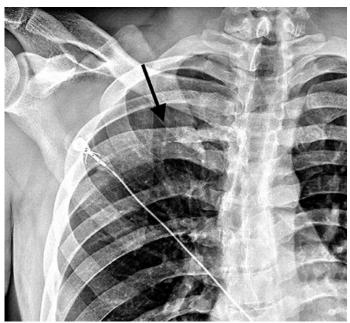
Rib anomalies: PA chest radiograph demonstrated congenital fusion of the posterior right 4th and 5th ribs (arrow).
